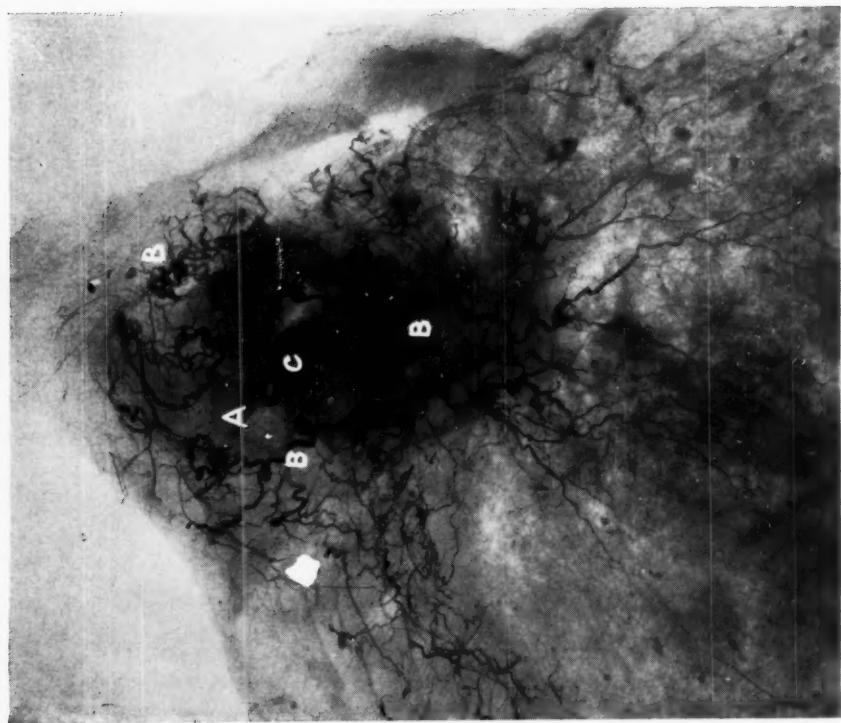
Lateral radiograph of a left upper lobe showing (A) tuberculous cavity; (B) bronchial arteries in considerable number in its vicinity; (C) a bronchial artery terminating in its wall.
